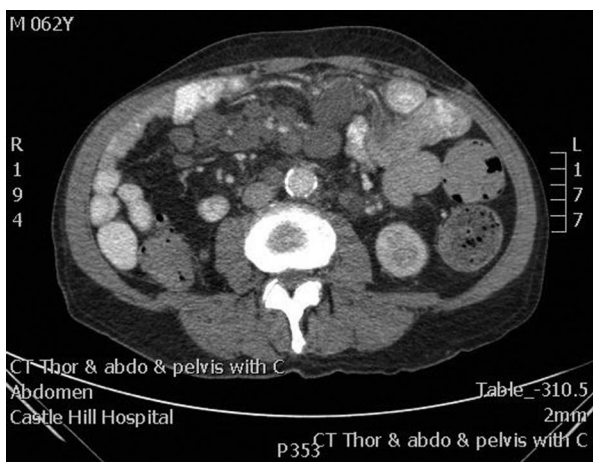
Lymphadenopathy on CT scan.
